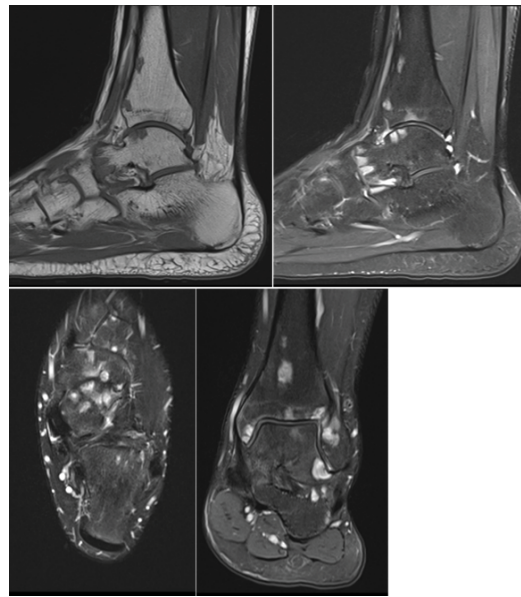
Magnetic resonance imaging of the left distal lower extremity. Sagittal T1-weighted (A), sagittal fat-suppressed T2-weighted (B), axial fat-suppressed T2-weighted (C), coronal fat-suppressed T2-weighted (D) images demonstrate multifocal marrow-replacing lesions involving the distal tibia, ankle, and multiple bones of the foot. The lesions are hypointense relative to normal marrow on T1-weighted images, hyperintense on fluid-sensitive sequences, and demonstrate avid enhancement following gadolinium administration. A small focus of extraosseous extension is present along the anterior aspect of the distal tibia.
